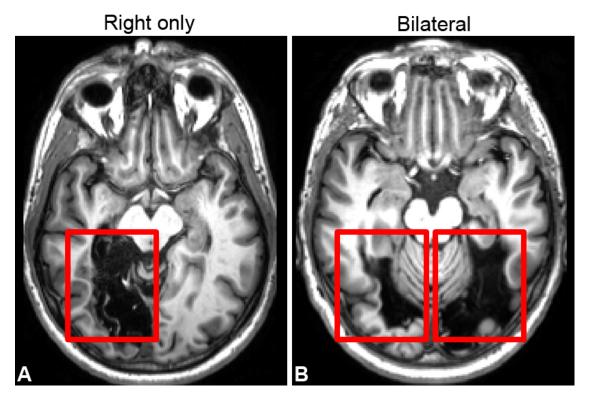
Axial images from T1-weighted magnetic resonance imaging of two patients with 'apperceptive' prosopagnosia. A) Unilateral inferior occipital damage in a 61 year-old man (R-IOT4) presenting with prosopagnosia, topographagnosia, and left quadrantanopia. B) MR axial images of bilateral inferior occipital damage in a 60 year-old man (B-IOT3) presenting with prosopagnosia, topographagnosia, dyschromatopsia and right hemianopia.
